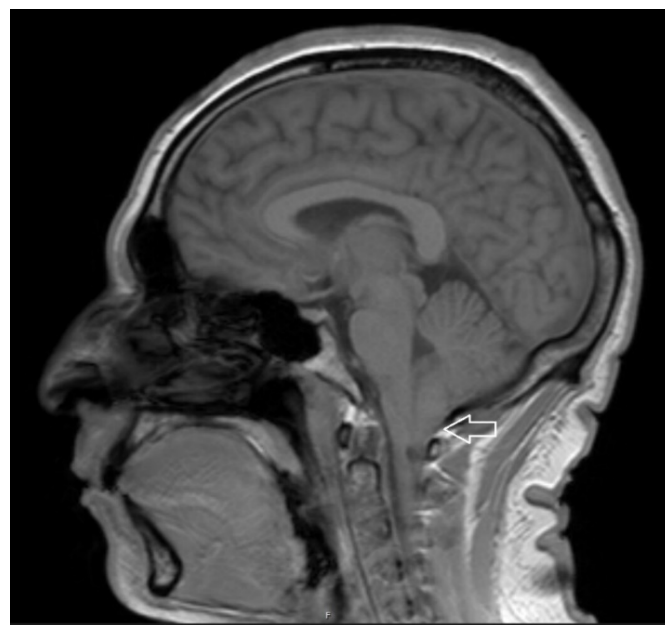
MR brain T1-weighted sagittal view identifying the cerebellar tonsillar herniation/low-lying pointing cerebellar tonsils below the foramen magnum that is typically seen in Chiari I malformations.
